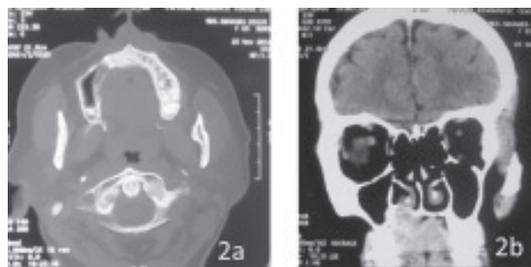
2a and 2b: CT scan showing extension of the lesion, 2a (axial section) and 2b (coronal section).
